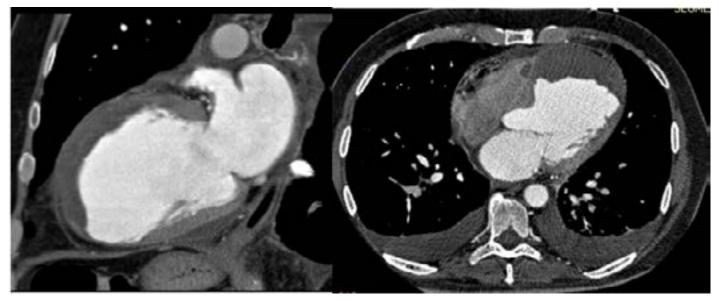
Cardiac CT scan showing large apical thrombus with thinned left ventricular wall.
